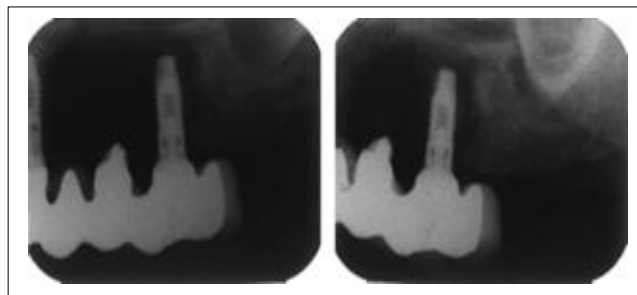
Periapical radiographs at presentation. Area of necrotic bone is evident around the left posterior implant, extending to the floor of the maxillary sinus.
